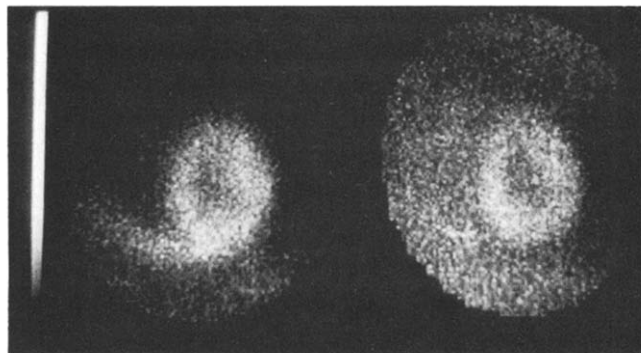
Patient 2. Stress (left) and redistribution (right) thallium scintigrams in the 40° left anterior oblique view. Thallium uptake in the septum is diminished during stress with resolution occurring on the redistribution image.
